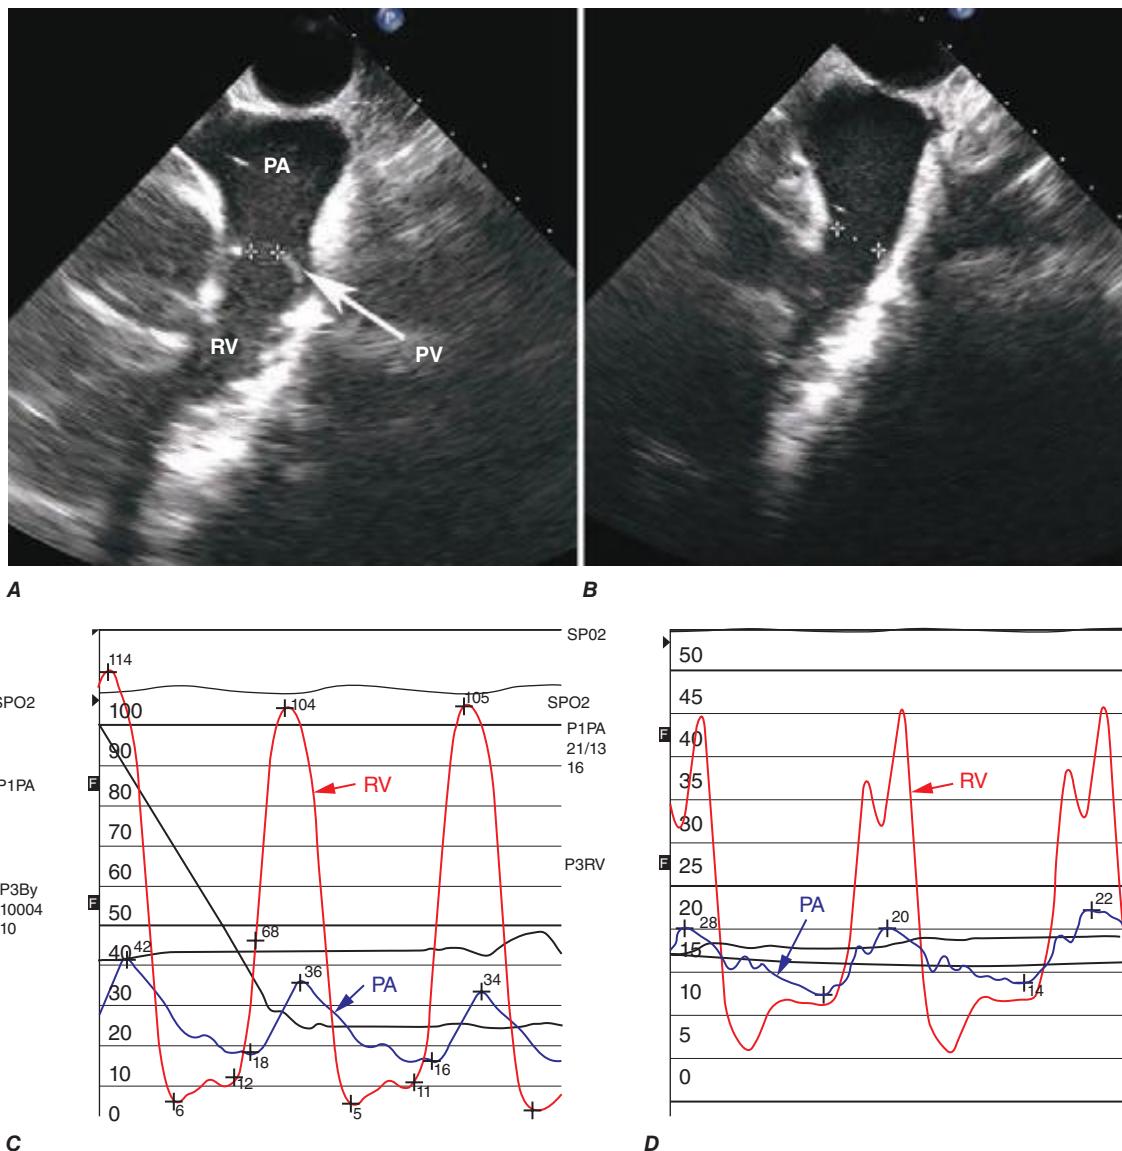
A. Transesophageal echocardiogram of a patient with severe pulmonary stenosis due to a mobile and doming pulmonary valve (PV). The pulmonary artery (PA) and the right ventricle (RV) are labeled. B. Following balloon valvuloplasty, the pulmonary valve orifice is larger. C. Simultaneous RV and PA pressure tracings before balloon valvuloplasty; the peak-to-peak gradient across the pulmonary valve is ~70 mmHg. D. After balloon valvuloplasty, the peak-to-peak gradient is reduced to ~25 mmHg.
